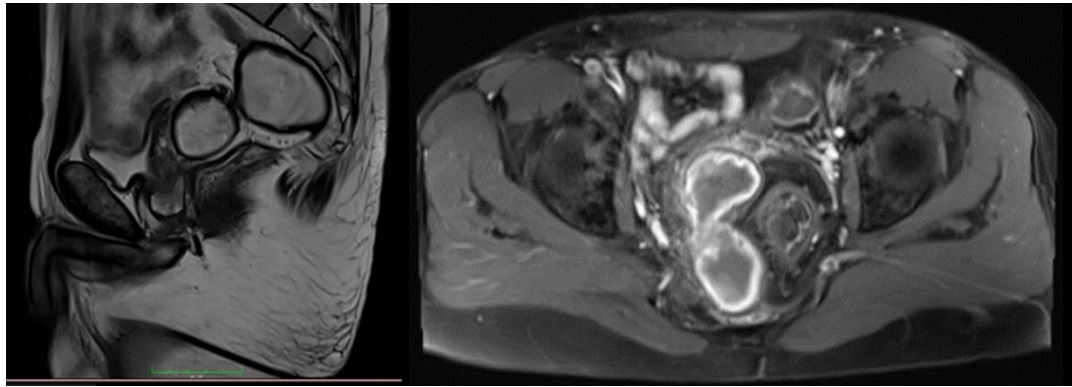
Pelvic magnetic resonance imaging: Hematoma in the pelvic region.
